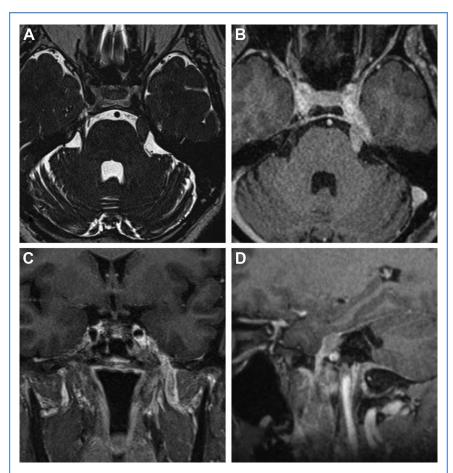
A–D: Preoperative magnetic resonance imaging (MRI) showing swelling of the left trigeminal nerve (A) and heterogeneously enhancing tumor with gadolinium extending along the left cavernous sinus and infratemporal fossa extending into the foramen ovale (B–D).
